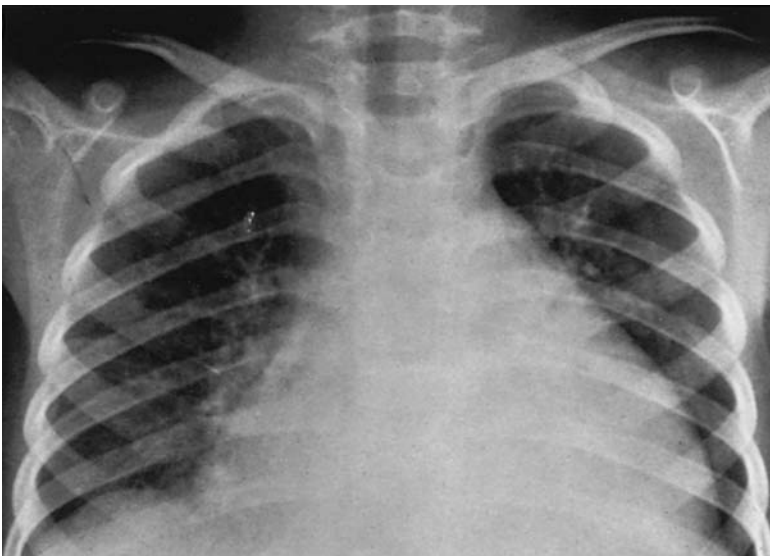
Chest radiograph of older child with congestive heart failure. Note cardiac enlargement and evidence of pulmonary venous congestion.
